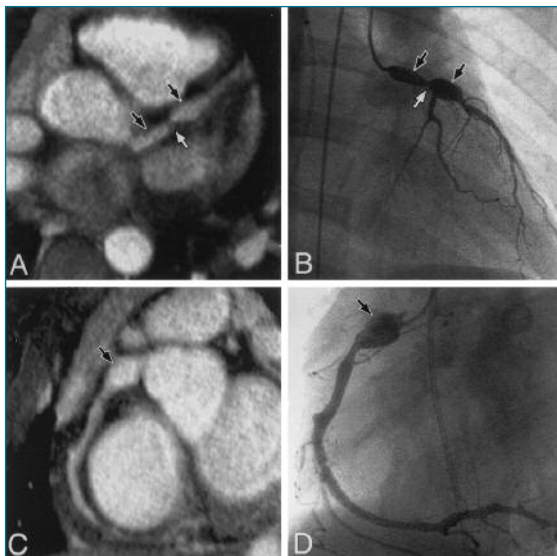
Multiplanar reformatted image of the left and right coronary arteries using MRI, demonstrating aneurysmal disease in the left and right coronary arterial systems. Reproduced with permission from Greil et al. Coronary magnetic resonance angiography in adolescents and young adults with Kawasaki Disease. *Circulation* 2002; 105 (8): 908-11.
